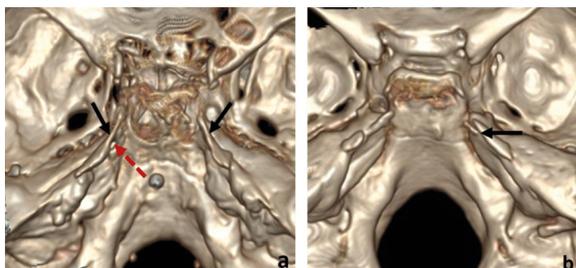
Volume rendered three-dimensional computed tomography images of ossified petrosphenoid ligament (PSL); A. Postero-superior view of the skull base showing bilateral partial ossification of PSL (black arrows) in a 68-year-old male. Dotted red arrow showing the petrous apex; B. Postero-superior view of the skull base showing partially ossified PSL on the right side (black arrow) in a 26-year-old female.
